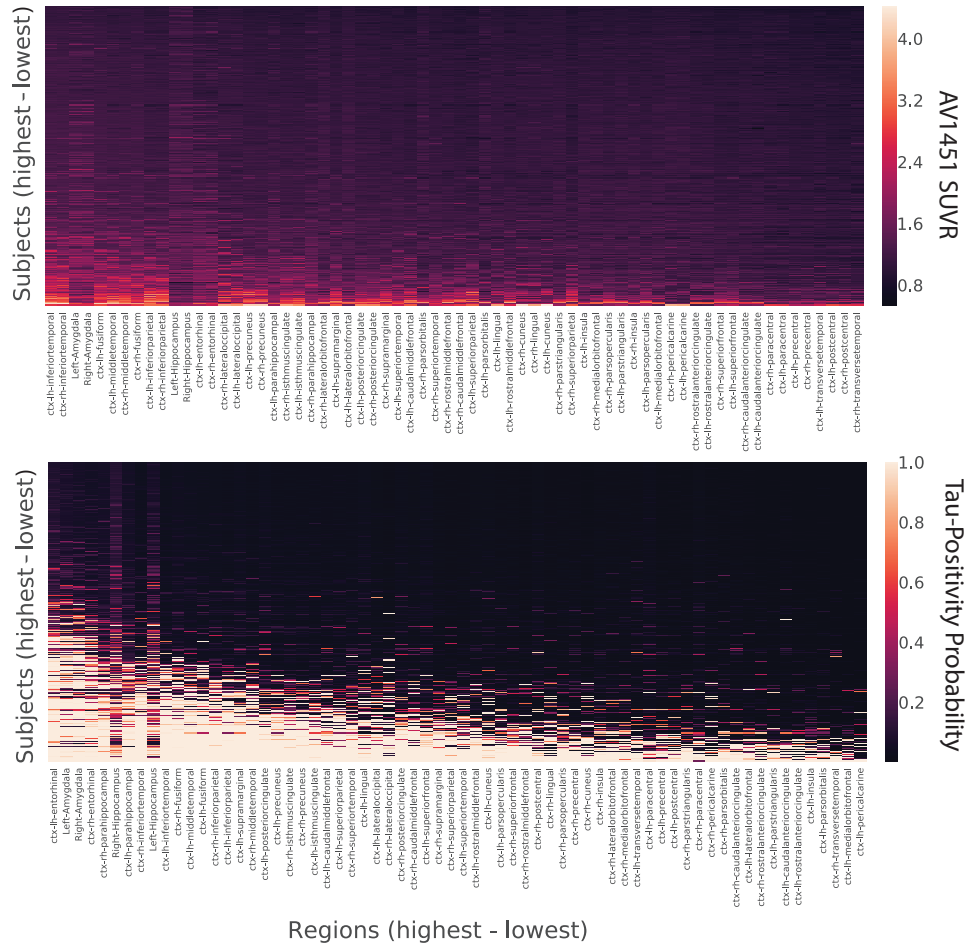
Tau-PET data before and after conversion to tau-positive probabilities. Each row is a subject sorted top-bottom by most to least overall tau. Each column is an ROI, sorted by least to most overall tau. Warmer colors represent higher SUVR values (top) or tau-positive probabilities (bottom). Conversion to tau-positive probabilities creates a sparse distribution of values demonstrating a progression. The order of ROIs resembles those described in the autopsy literature.
